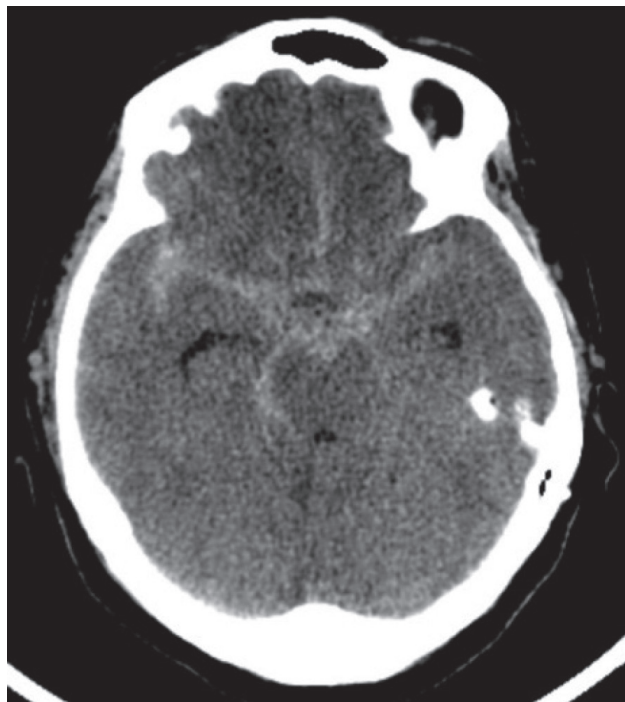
Cranial Computed tomography (axial) demonstrating diffuse subarachnoid hemorrhage, involving basal cisterns and Sylvian fissures. Source: main author's personal archive
